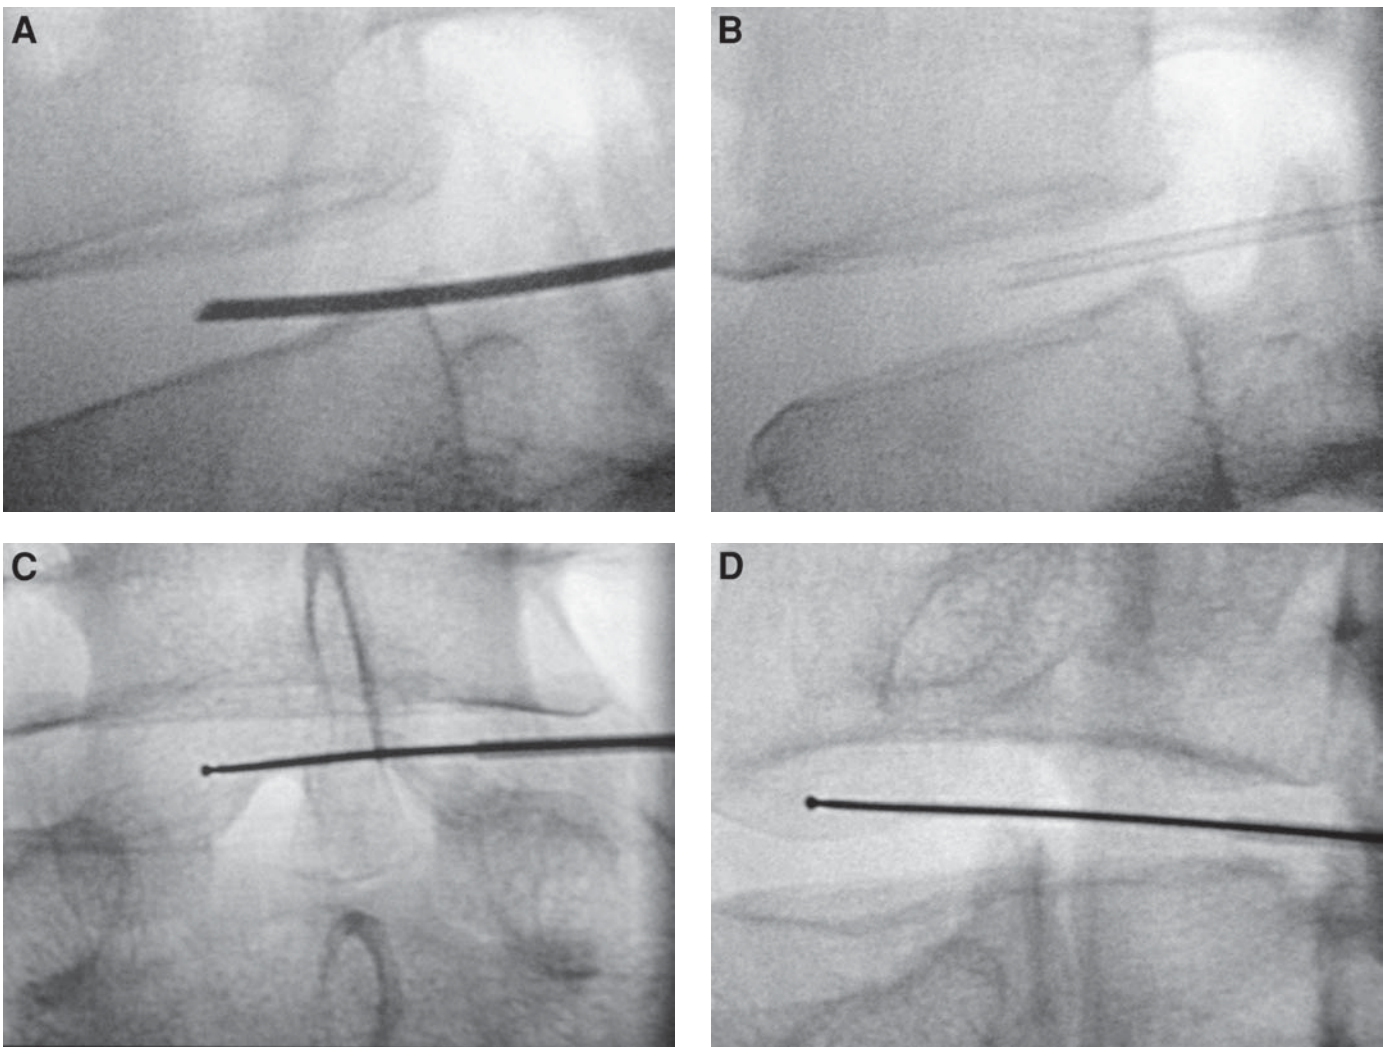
(A) Lateral image of nucleoplasty introducer needle within the disc. (B) The inner stylet is removed and the Spine Wand is introduced. (C) The Spine Wand is advanced until resistance is felt. This usually indicates the nuclear–annular interface. (D) The II is rotated until the X-ray beam is perpendicular to the needle to ensure that the Spine Wand does not go beyond the confines of the disc.
